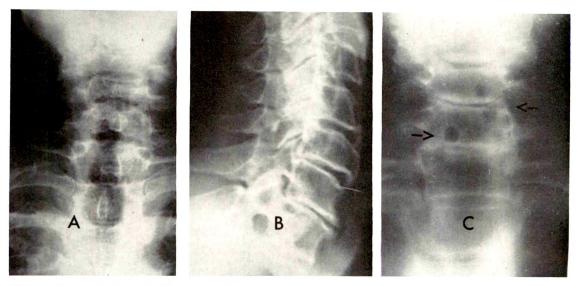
Case II. (A and B) Conventional cervical spine roentgenograms showing moderate osteoarthritic changes. (C) Polydirectional laminagram in anteroposterior section showing punched out lesions of the fifth and sixth cervical vertebrae.
